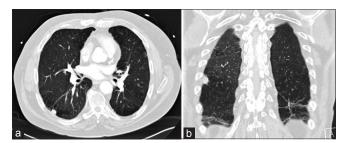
Selected axial (a) and coronal (b) computed tomography images from a CT aorta study Performed 2 months following myocardial perfusion scintigraphy. An incidental right lower lobe opacity, now measuring 12 mm is seen. Urgent further investigation was advised due to suspicion for malignancy
